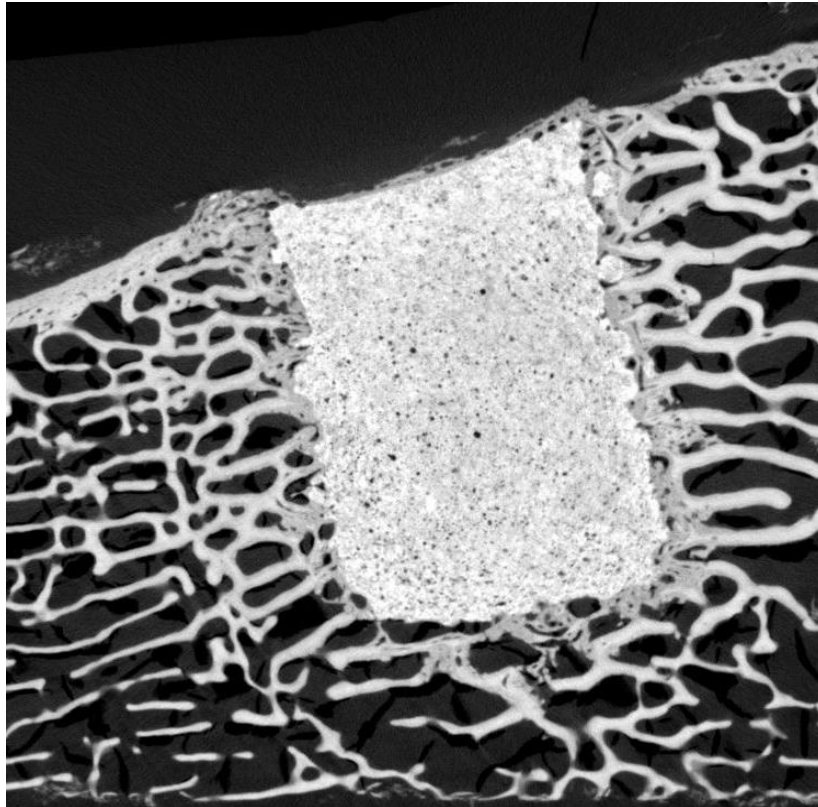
X-ray microtomography slice through the implanted HydroSet™ within bone. The contrast has been increased to highlight differences between new and old bone.
